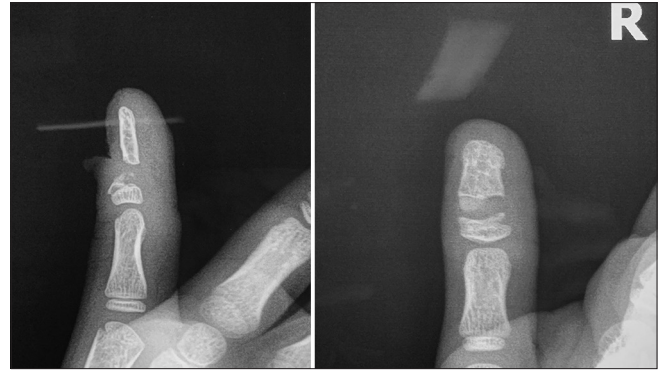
Conventional radiography suggests chronic Seymour's fracture and nonunion
